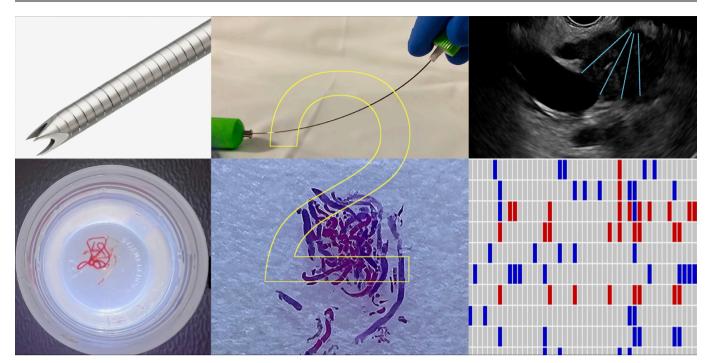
Graphical abstract demonstrating, Franseen-tip needle, stylet-retraction technique and fanning manoeuvre (upper panel, left to right); pancreatic cancer tissue collected at endoscopic ultrasound in 10% formalin, formalin-fixed paraffin embedded cell block and molecular profiling (lower panel, left to right), can be achieved with two dedicated fine needle biopsy passes.
